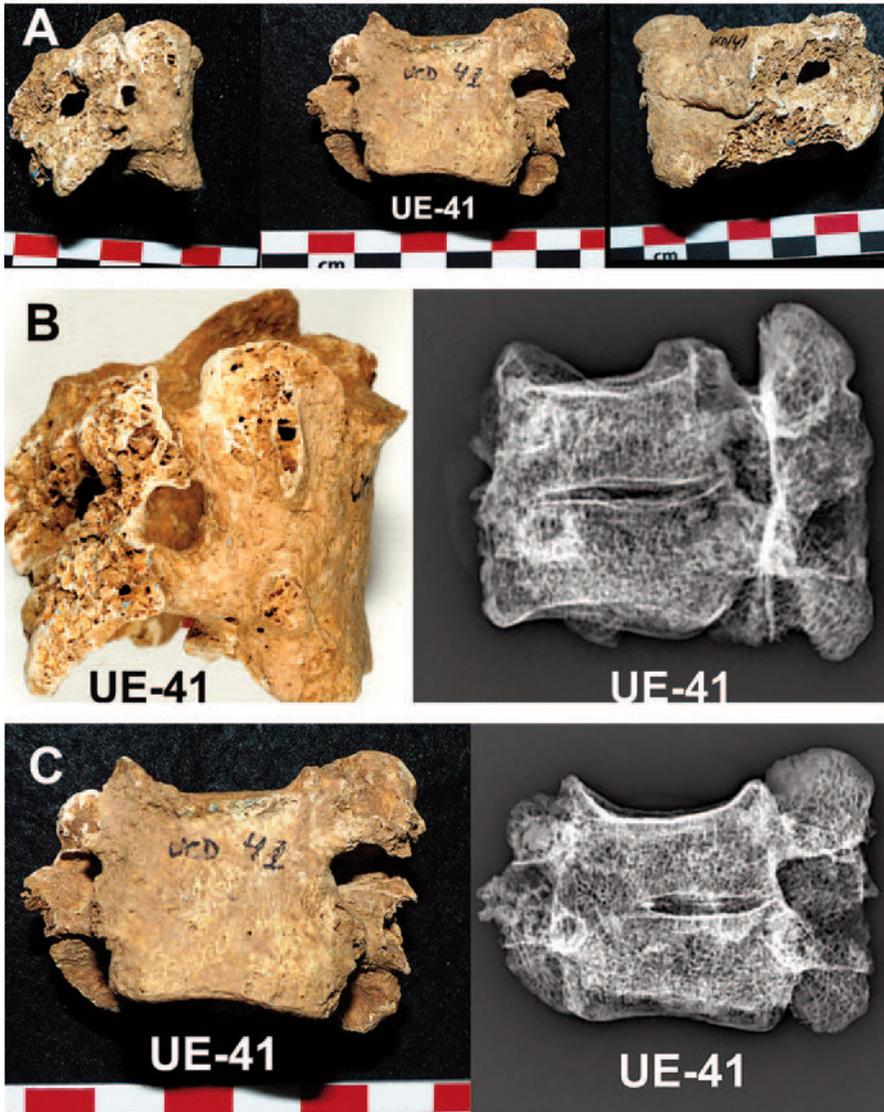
UE 41. Fusion between C2 and C3. (A) Lateral and anterior view. (B) Lateral view and Lat. X-rays. (C) Anterior view and AP X-rays.
